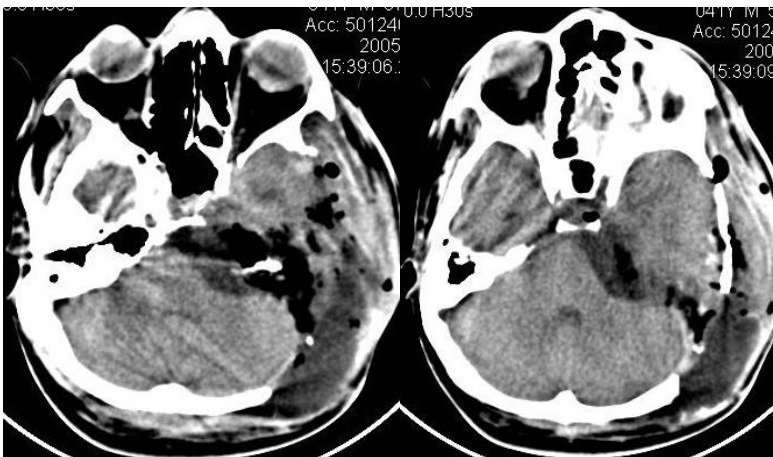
Immediate postoperative CT scans showing the bone drilling used for combined transpetrosal approach and no evidence of residual tumour. This
